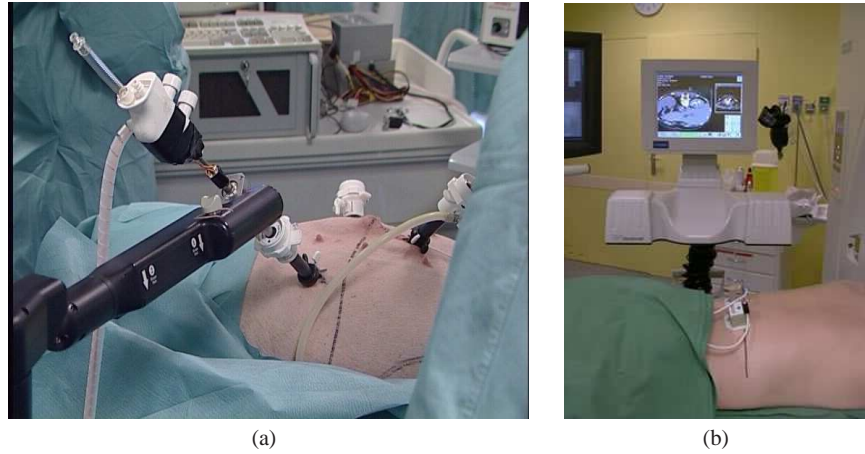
(a) The laparoscopic experimental setup. The instrument is mounted on the end effector of a surgical robot and inserted through the abdominal wall while the laparoscope is inserted through another insertion point. (b) An image-guidance with CT scanners feedback control during the percutaneous insertion of a radio-frequency needle.
